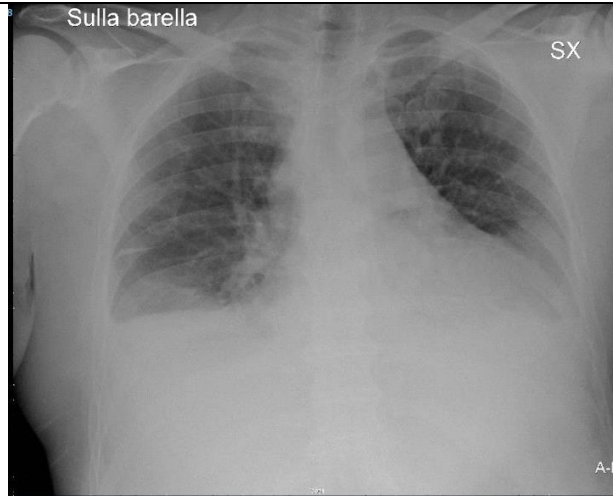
Chest x-ray shows a pattern of right unilateral pleural effusion together with a consensual area of right basal pulmonary atelectasis.
